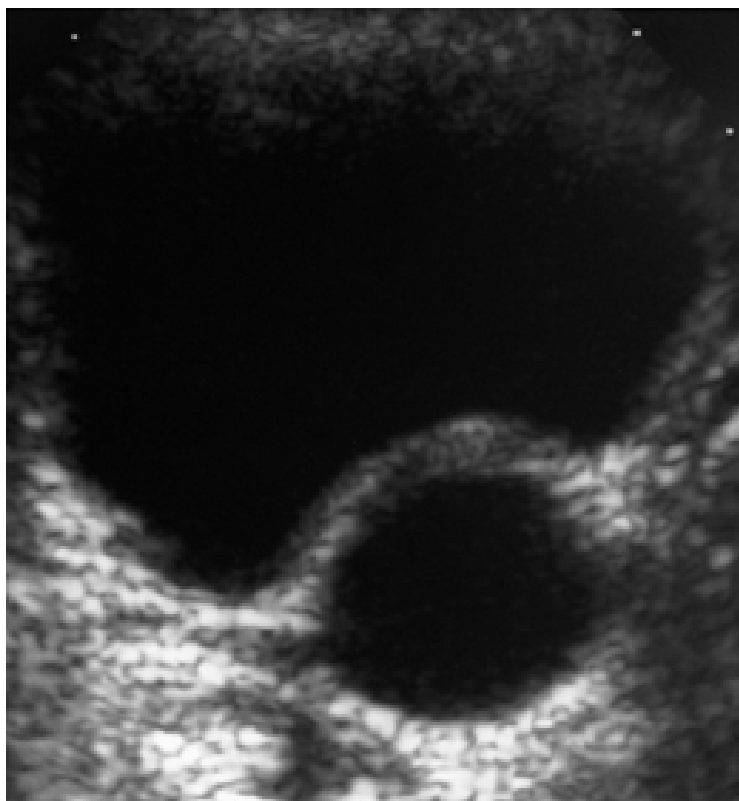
30. Ultrasound demonstrating dilated ectopic ureter behind posterior bladder wall.
